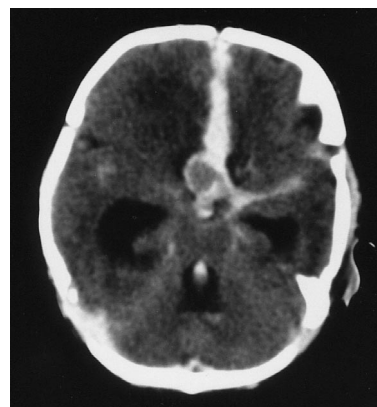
CT scan shows extensive subarachnoid and intraventricular haemorrhage with a localised haematoma in the anterior interhemispheric fissure. The aneurysm is represented by an area of relative hypodensity within the haematoma
